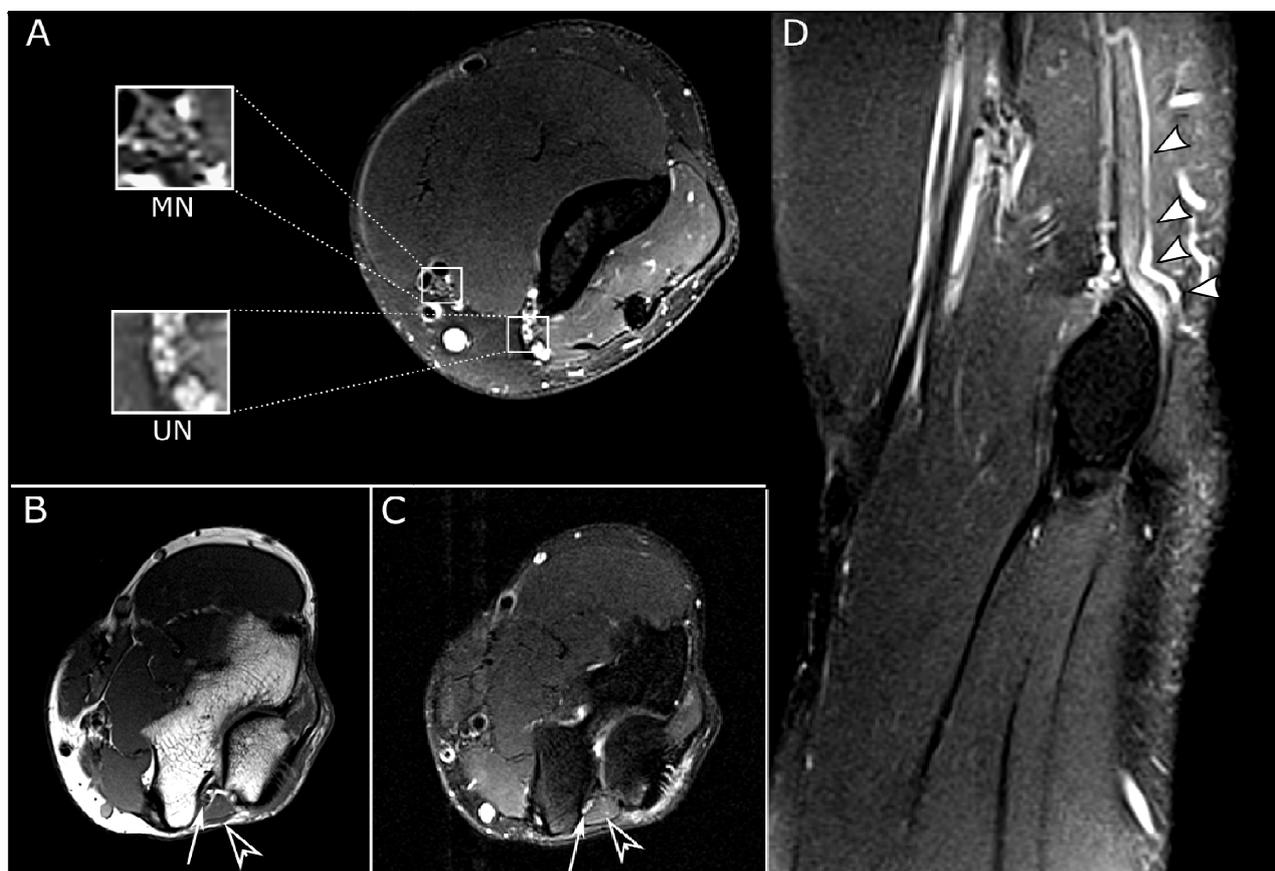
Nerve impingement. Axial T2 fat saturated image (A) displays marked hyperintensity in the ulnar nerve (UN) at the level of the distal humerus. This can be compared to the normal signal median nerve (MN). T1-weighted image at the level of the cubital tunnel (B) demonstrates an accessory anconeus epitrochlearis muscle (open arrowhead) along the medial aspect of the olecranon, adjacent to the ulnar nerve (small arrow). Axial and coronal T2 fat saturated images (C and D) demonstrate focal compression of the ulnar nerve at the level of the accessory muscle.
